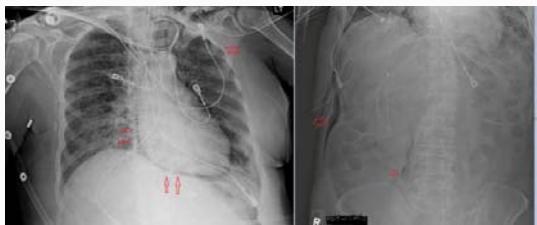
a) Chest X-ray showing an 8.5 mm left pneumothorax and pneumomediastinum. b) Abdominal X-ray showing gas tracking in the right lateral abdominal wall as well as gas in the right retroperitoneum presumably along the psoas muscle.
